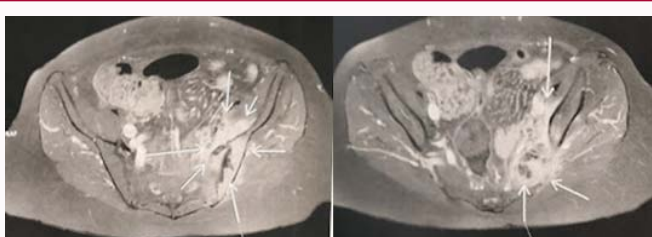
CT views of the pelvis showing a heterogeneous appearance of the left sacroiliac joint.
